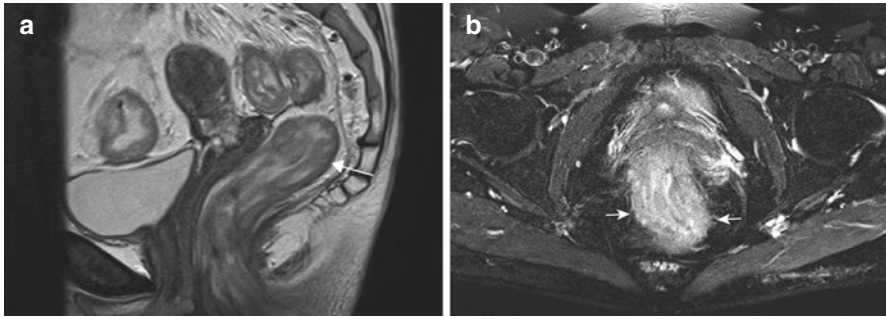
Proctitis with wall thickening including abnormal stratification on a sagittal T2-weighted sequence (a) and perimural infiltration (short arrows) on an oblique axial fat-suppressed T2-weighted sequence (b). The T1 fat-suppressed contrast-enhanced sequence showed perimural enhancement (not shown here)
